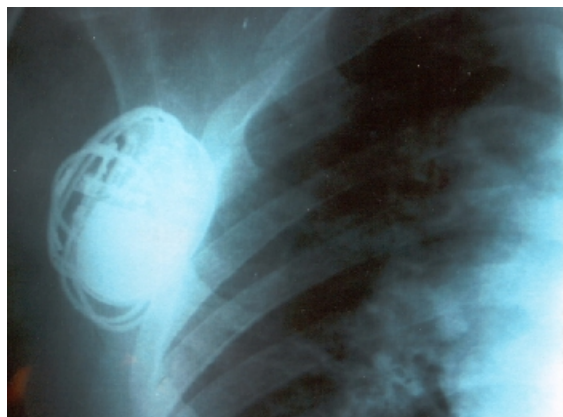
Detail of posteroanterior chest radiography showing the pulse generator and the completely wrapped pacemaker lead.
